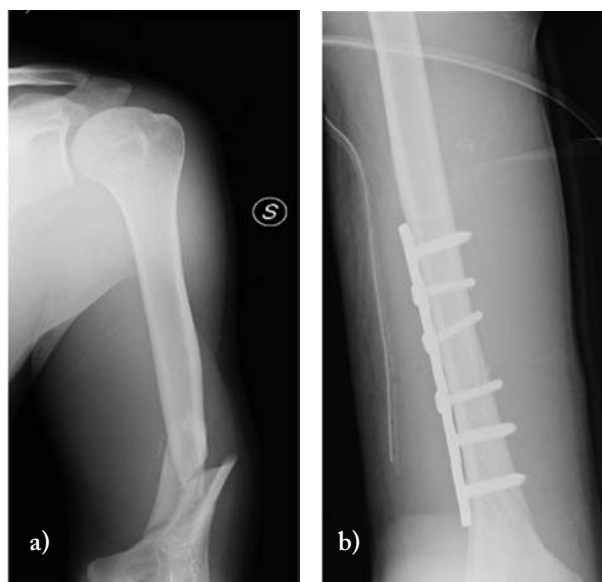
a, b) Anteroposterior X-rays of the Spiral fracture of the humerus and his treatment whit plating
